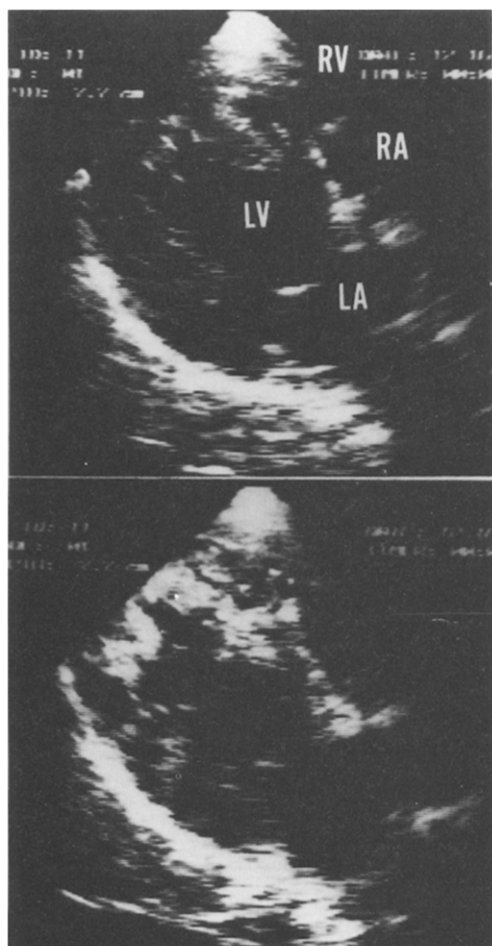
Top, Parasternal four chamber view during control state. Middle, Injection into the great cardiac vein results in the appearance of bright contrast in the right atrium (RA) and right ventricle (RV). Bottom, Several cardiac cycles later, the contrast in the right side of the heart has disappeared; a small amount of contrast material is still seen within the left ventricular (LV) cavity, but not within the left atrium (LA). Although opacification of left ventricular myocardium had been obvious on short-axis views, no such effect can be seen in the long-axis view because the echocardiographic plane fails to transsect the area of myocardial contrast uptake.
